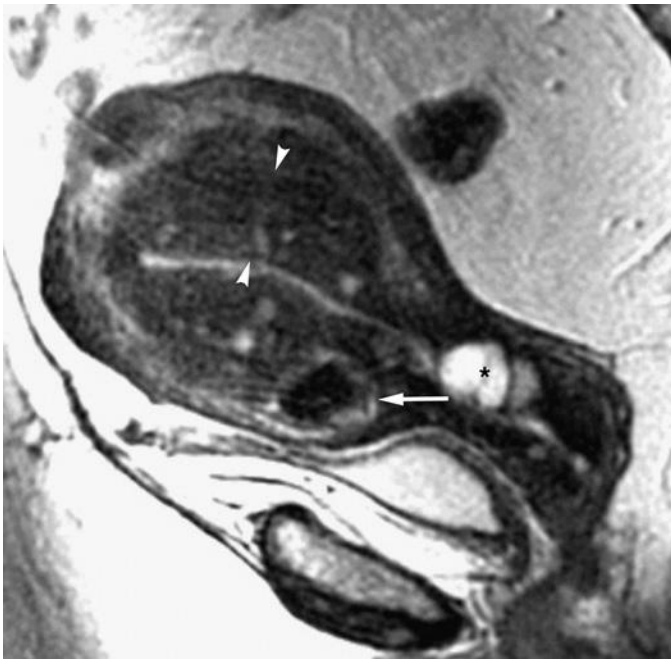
Leiomyomas and adenomyosis. Sagittal T2-weighted image demonstrates a pseudocapsule of high signal intensity around a well-defined myometrial mass (*arrow*) in the anterior wall of the lower uterine segment, diagnostic of a leiomyoma. The low signal intensity junctional zone (*arrowheads*) is diffusely thickened and has the characteristic starry sky appearance with numerous punctate foci of high signal intensity consistent with adenomyosis. *Asterisk*, nabothian cyst.
